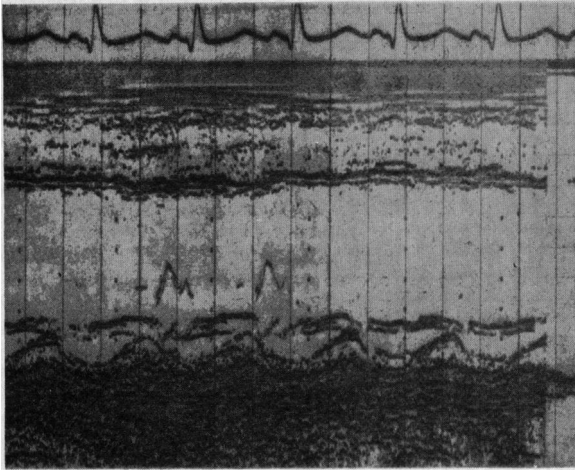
Echocardiogram with transducer beam directed through the left ventricular cavity showing decreased septal motion and thickness with an enlarged ventricular diastolic diameter.
